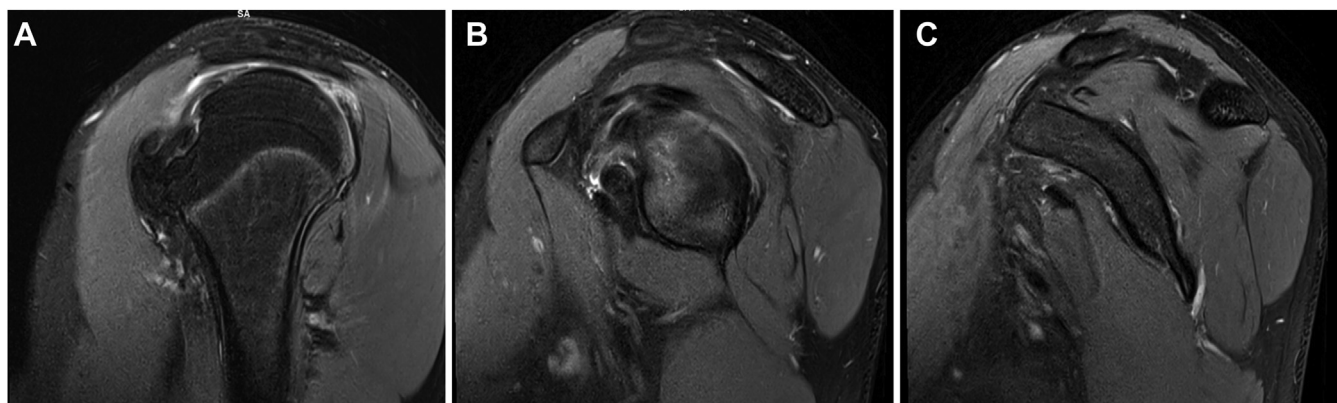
Preoperative T2 sequence sagittal cuts of magnetic resonance imaging of the left shoulder. (A) Lateral sagittal cut showing the supraspinatus and infraspinatus attaching to the greater tuberosity malunion at the anterior aspect of the humerus, anterior to the lesser tuberosity. (B) Midsection sagittal cut showing the abnormal positioning of the supraspinatus and infraspinatus tendons anterosuperior. (C) Medial sagittal cut showing the maintained muscle bellies of the supraspinatus, infraspinatus, and subscapularis.
